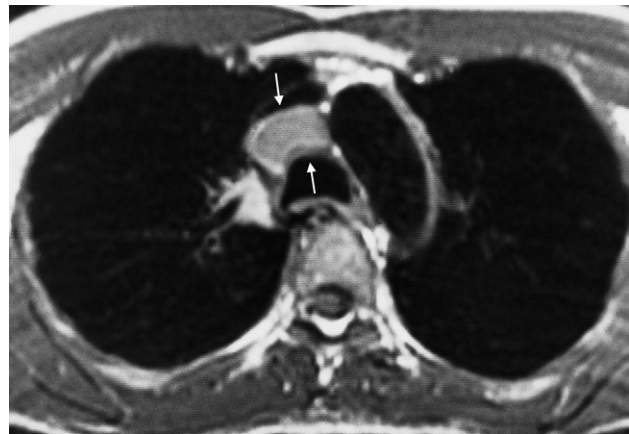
MRI (T1-weighted) showing enlarged node (arrows) which stands out clearly against the background of no signal in the lung, trachea and aorta.
